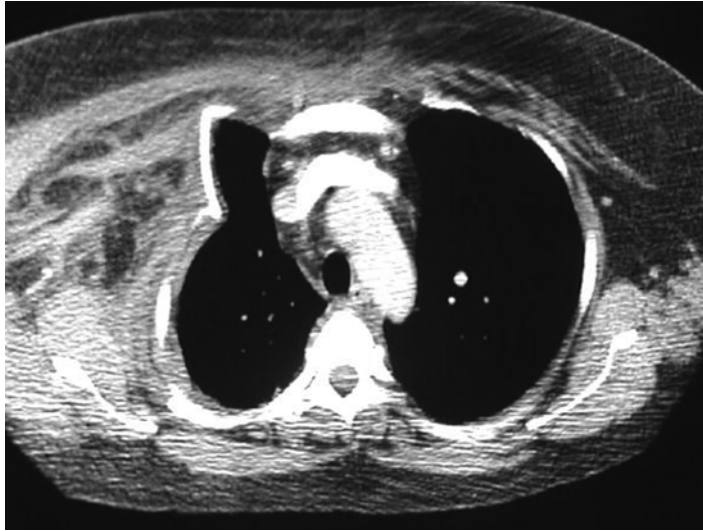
A CT scan of a polytrauma patient with a severe right-sided chest injury, a flail segment, significant intrusion of the chest wall, and subsequent severe compromise of the thoracic cavity and respiratory function. This patient represents, with the current level of knowledge
